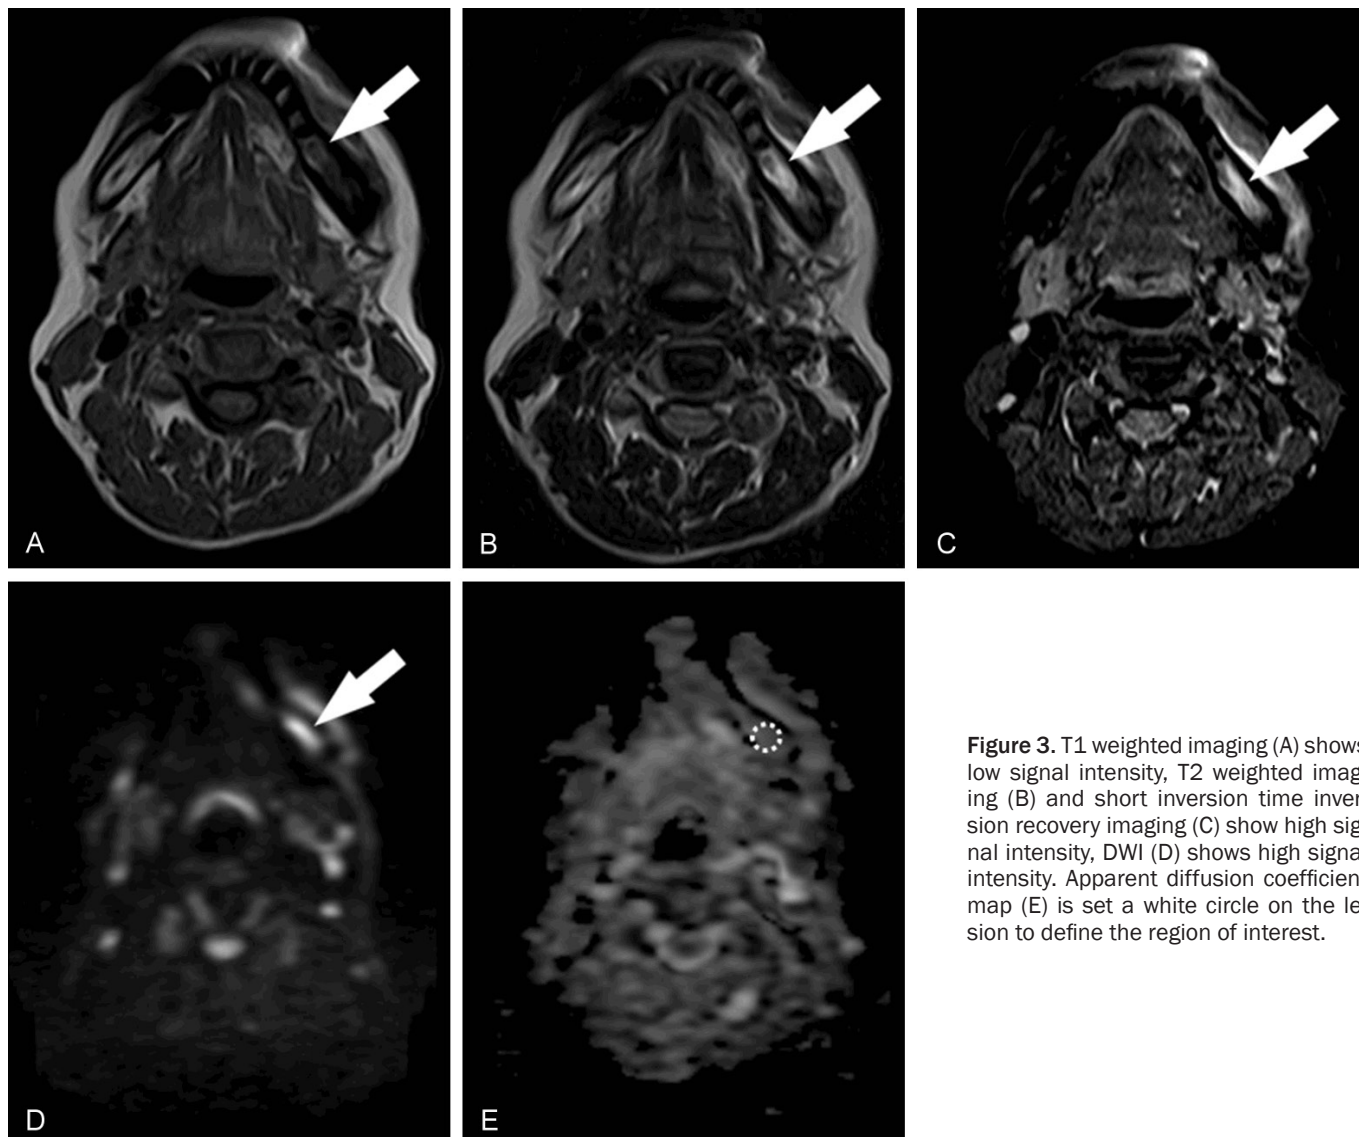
T1 weighted imaging (A) shows low signal intensity, T2 weighted imaging (B) and short inversion time inversion recovery imaging (C) show high signal intensity, DWI (D) shows high signal intensity. Apparent diffusion coefficient map (E) is set a white circle on the lesion to define the region of interest.
